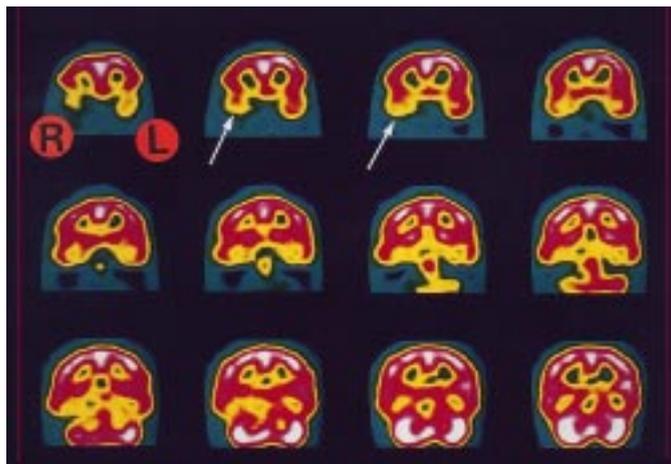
Coronal slices of FP's first SPECT scan showing well defined right temporal hypometabolism.
